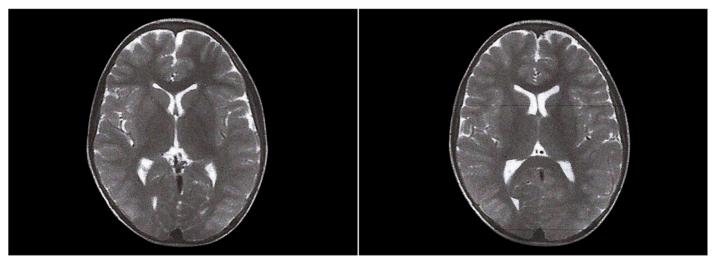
Vasogenic edema in the right occipital lobe on T2A cranial MR imagings.
